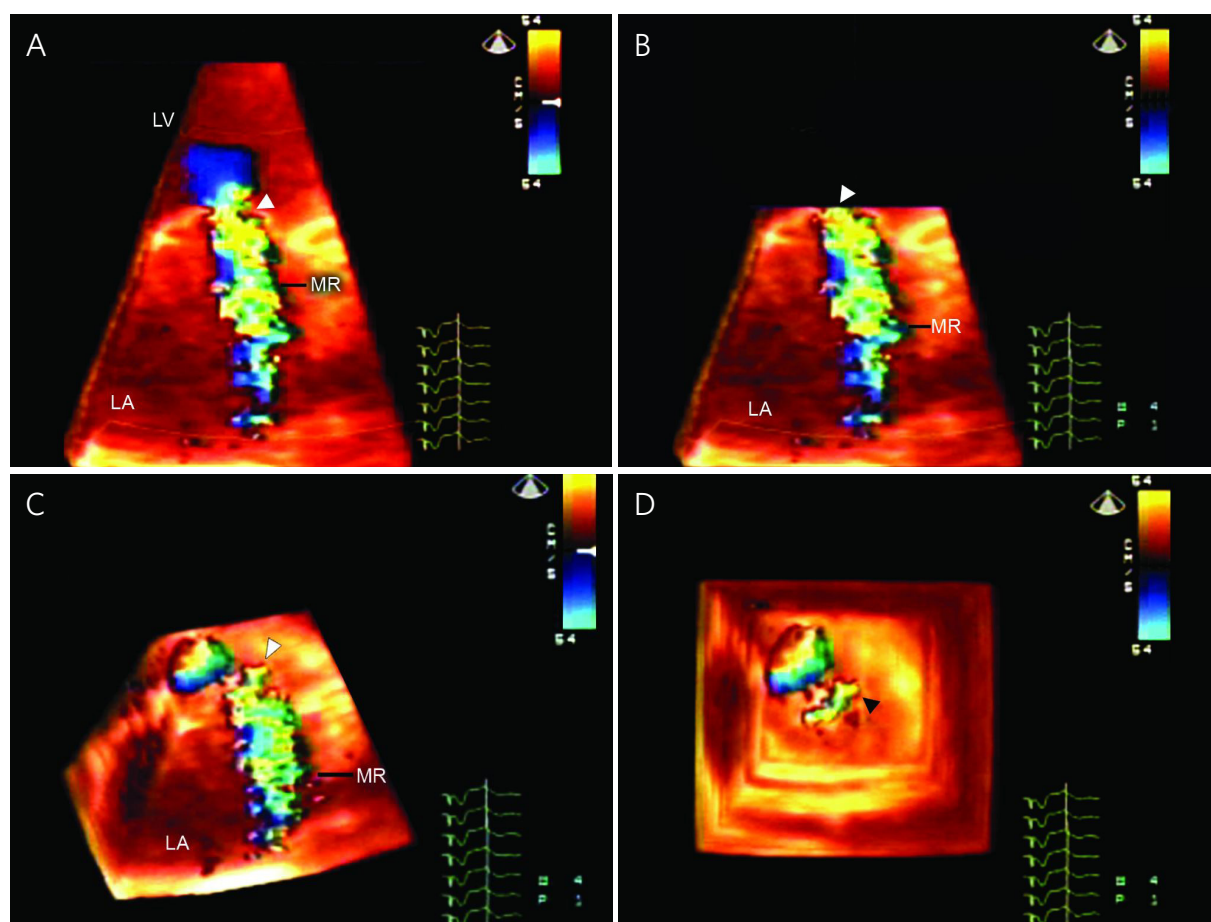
A-D: Live/real-time three-dimensional color Doppler transthoracic echocardiographic technique for assessment of vena contracta area. Three-dimensional color Doppler dataset showing MR (A) cropped from top to the level of the vena contracta (arrowhead, B) and tilted to view it en face (arrowheads in C and D). The vena contracta area is then measured by planimetry. MR: mitral regurgitation. Reproduced with permission from Khanna *et al.*^[30]
